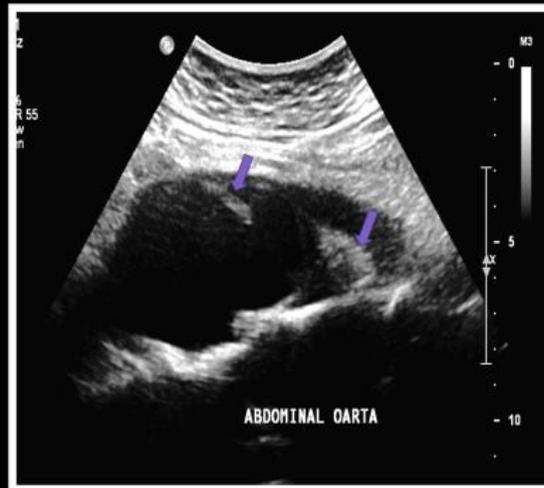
abdominal ultrasound fusiform abdominal aortic aneurysm below the origin of renal arteries with eccentric mural thrombus (arrows)
